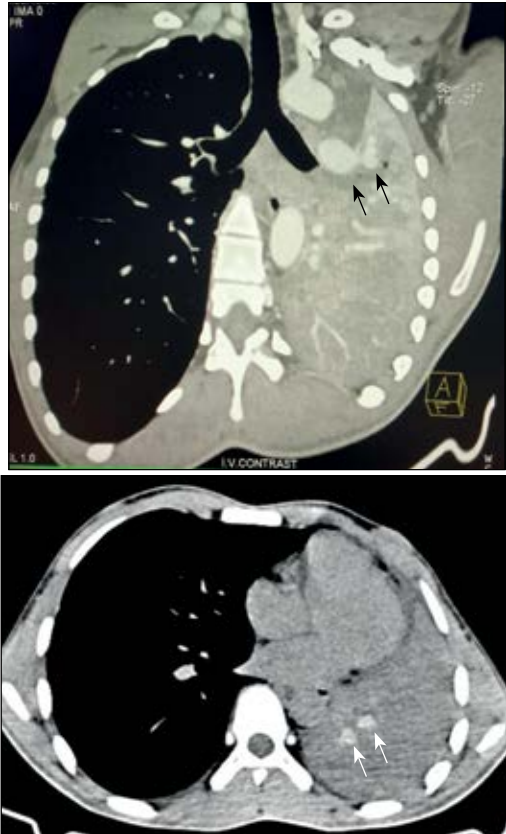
(A). Coronal reconstruction of contrast-enhanced computed tomography of the chest showing complete collapse of the left lung due to mucus plug in the left main bronchus (black arrows), and (B) non-contrast computed tomography of the chest showing collapse of the left lung with high attenuation mucus (HAM) in the segmental bronchi of the left lower lobe (white arrows).
